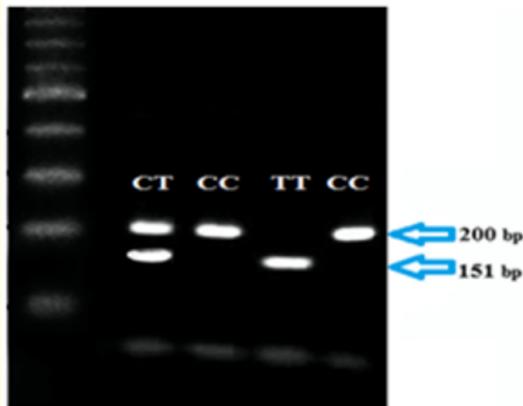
PCR-RFLP data after enzyme digestion by HinfI on electrophoresis gel for NQO1 gene. the HinfI digestion resulted in one fragment of 200 bp for wild type (CC); two fragments of 151 bp and 49 bp for homozygote (TT); and three fragments of 200 bp, 151 bp and 49 bp for heterozygous (CT). Fragment of 49 bp was not visible in electrophoresis gel.
